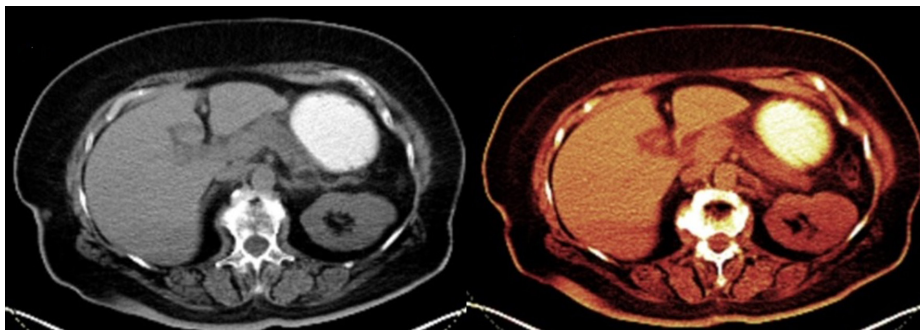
Thirteen months post-cryoablation, a follow-up PET-CT scan showed almost complete disappearance of the pancreatic mass with no suspicious FDG uptake. PET-CT, positron emission tomography-computed tomography; FDG, fluorodeoxyglucose.
